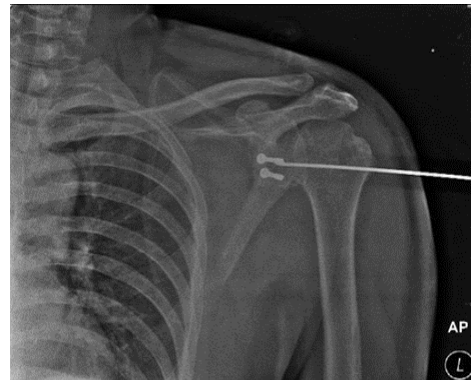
Plain X-ray post surgery showed repaired glenohumeral joint
